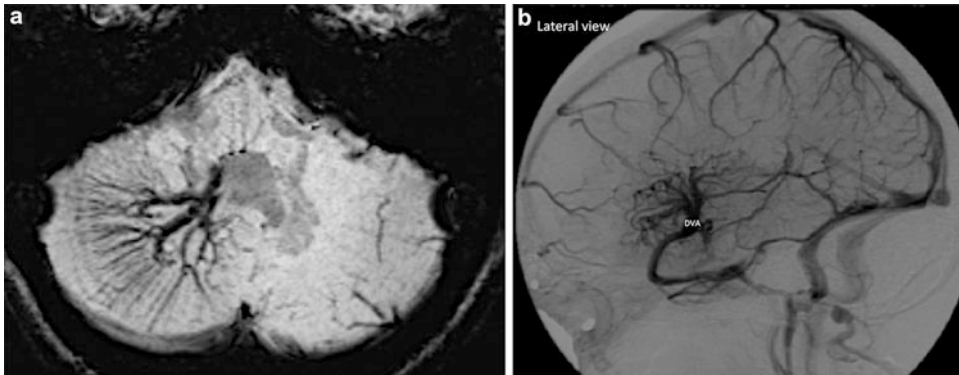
(a, b) Developmental venous anomaly (DVA). (a) Axial SWI MR image showing a large cerebellar DVA. (b) DSA venous phase lateral view demonstrating a superficial
